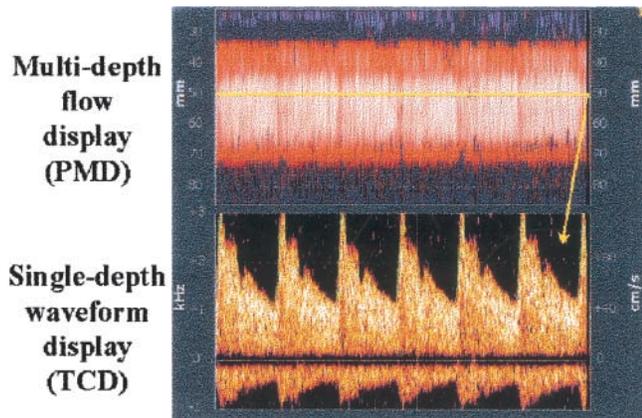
Simultaneous power motion mode Doppler/transcranial Doppler (PMD/TCD) display. The yellow line indicates depth selection for TCD display controlled by an operator. The PMD display shows depth of insonation in mm, and the TCD display shows frequency/velocity in kHz and cm/s.
